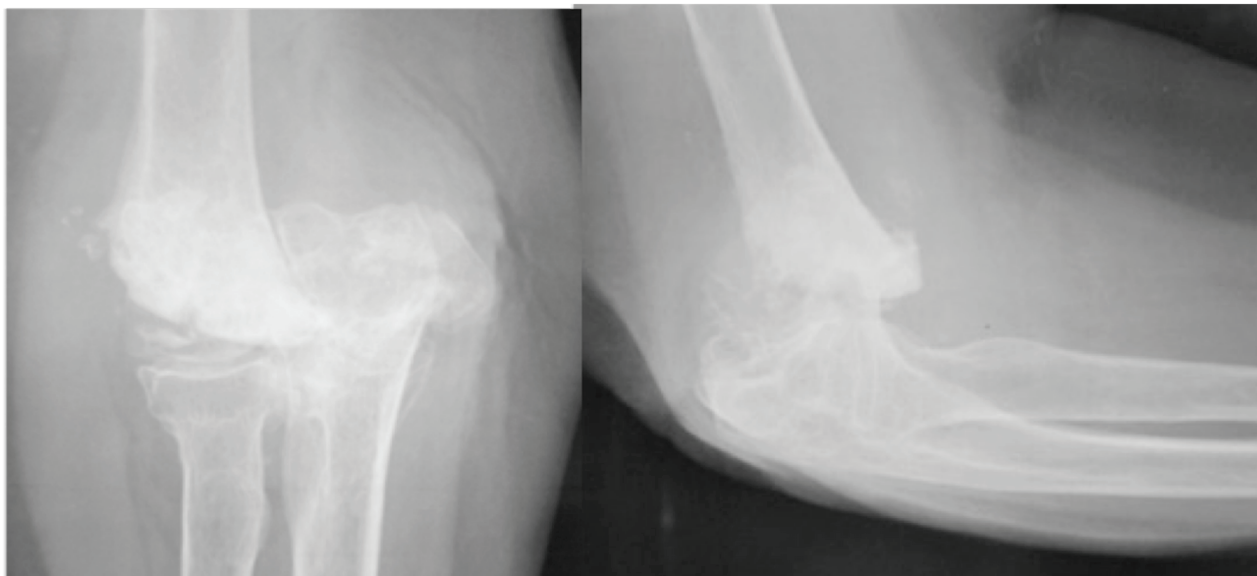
X-rays – Type C fracture in 83 years-old female.
